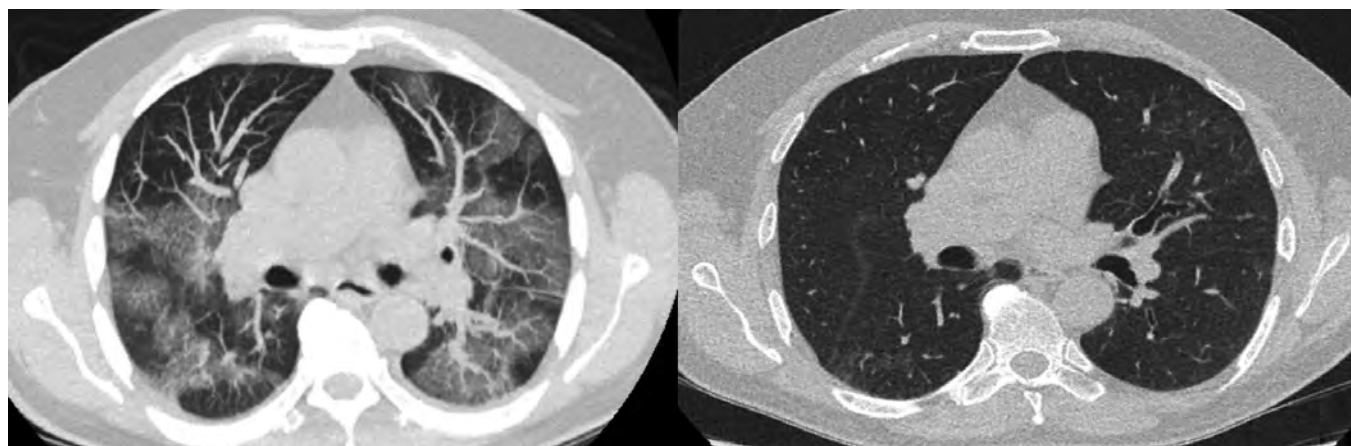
CT-Scan of a patient with active COVID-19 infection before and one month after treatment with a combination of tocilizumab and anakinra.
